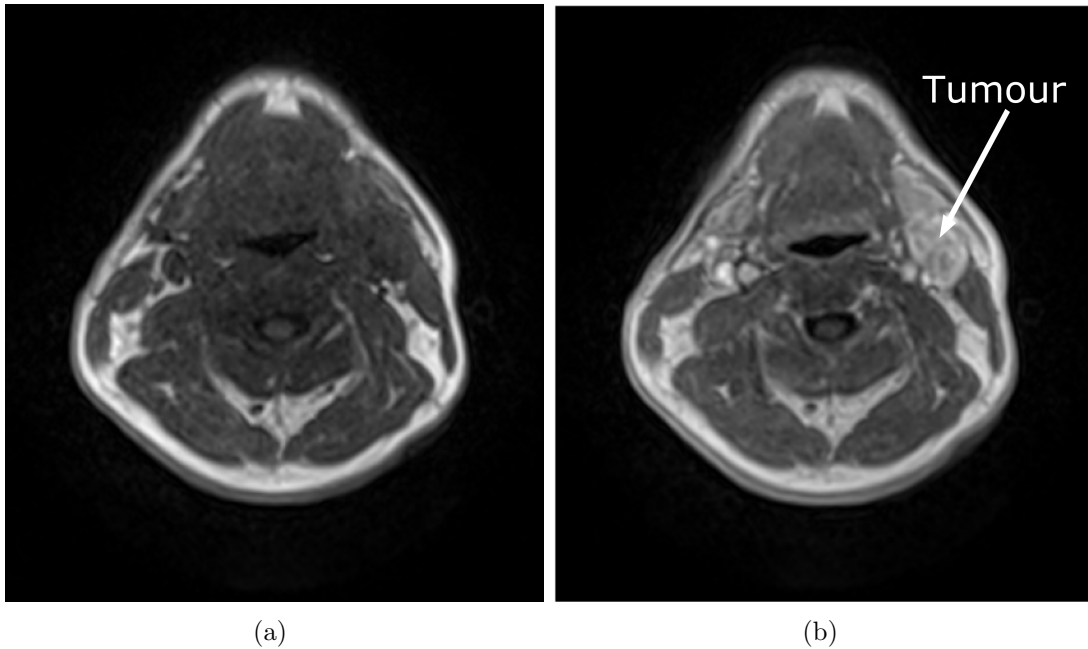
A dynamic contrast-enhanced magnetic resonance image of a head and neck cancer patient a) before and b) after contrast agent was injected. The arrow indicates the location of the patient’s tumour.
